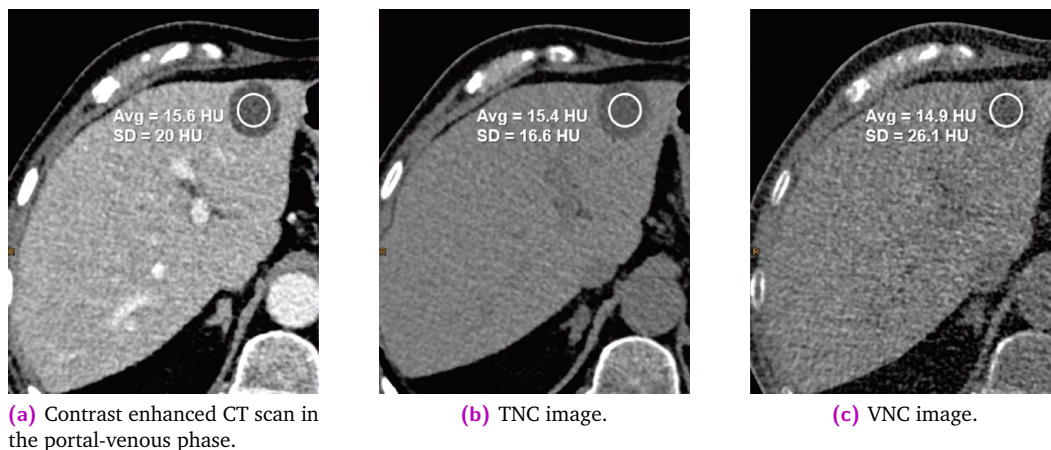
Magnified axial CT slice of a 79-year-old male patient with a cystic lesion in the left liver lobe with a diameter of 28 mm (modified from [282]).
